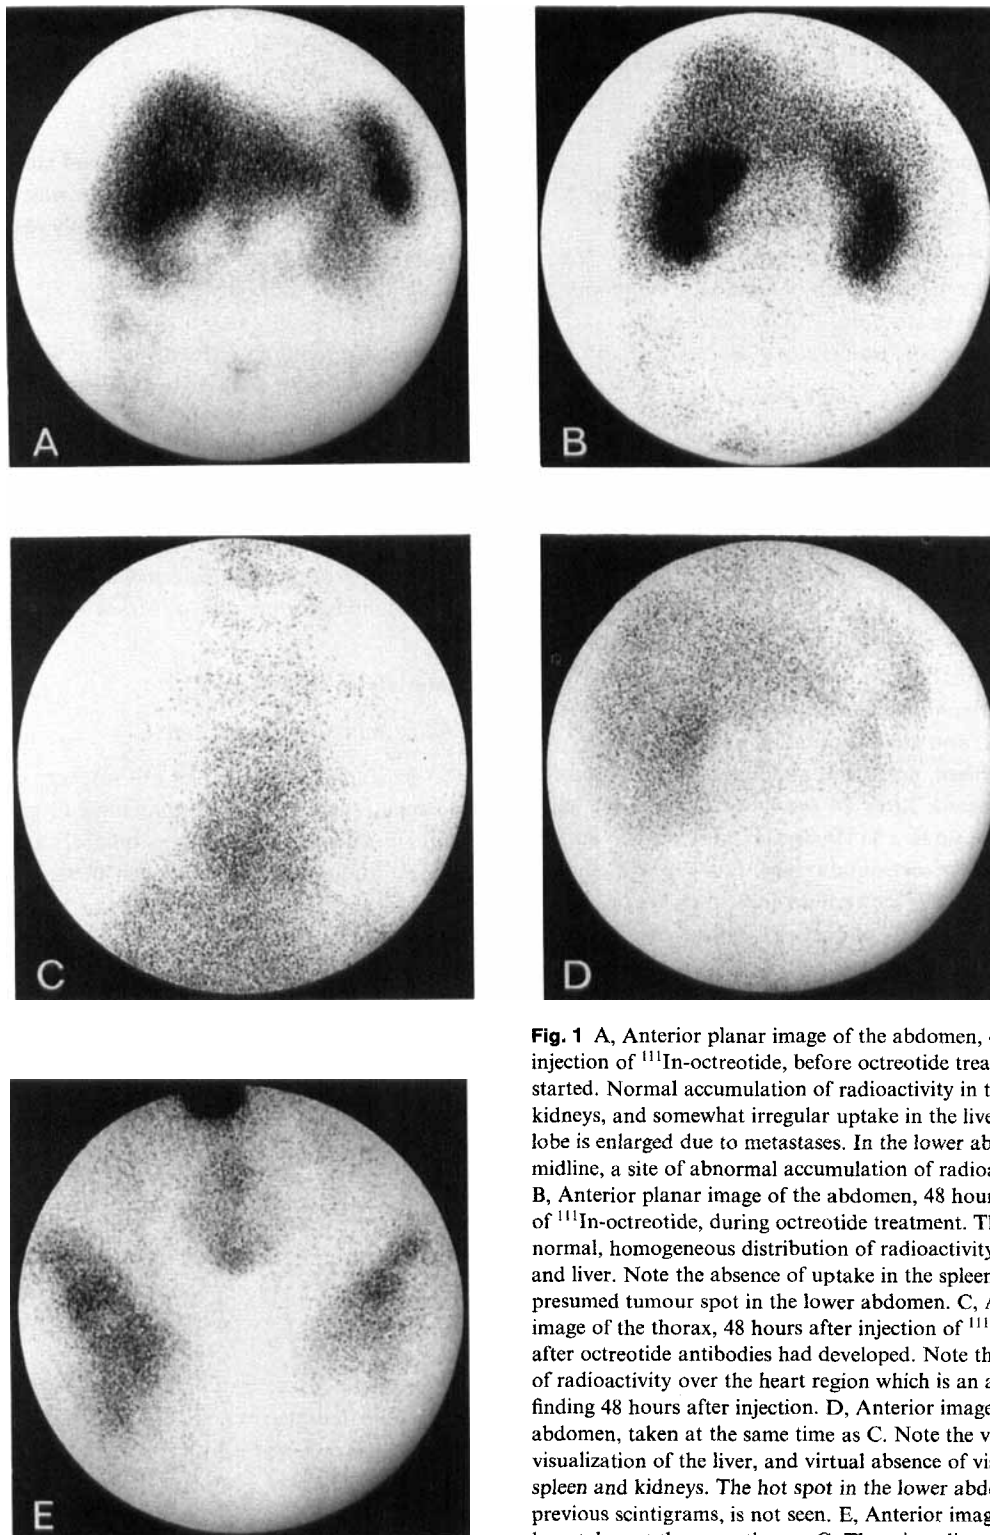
A, Anterior planar image of the abdomen, 48 hours after injection of ^{111}In -octreotide, before octreotide treatment was started. Normal accumulation of radioactivity in the spleen and kidneys, and somewhat irregular uptake in the liver. The left liver lobe is enlarged due to metastases. In the lower abdomen in the midline, a site of abnormal accumulation of radioactivity is seen. B, Anterior planar image of the abdomen, 48 hours after injection of ^{111}In -octreotide, during octreotide treatment. There is a normal, homogeneous distribution of radioactivity in the kidneys and liver. Note the absence of uptake in the spleen and in the presumed tumour spot in the lower abdomen. C, Anterior planar image of the thorax, 48 hours after injection of ^{111}In -octreotide, after octreotide antibodies had developed. Note the accumulation of radioactivity over the heart region which is an abnormal finding 48 hours after injection. D, Anterior image of the abdomen, taken at the same time as C. Note the very faint visualization of the liver, and virtual absence of visualization of spleen and kidneys. The hot spot in the lower abdomen seen on previous scintigrams, is not seen. E, Anterior image of the upper legs, taken at the same time as C. There is radioactivity in the urethra and penis (upper edge of the image), and clearly increased radioactivity at the sites of daily injections of octreotide in both upper legs.
